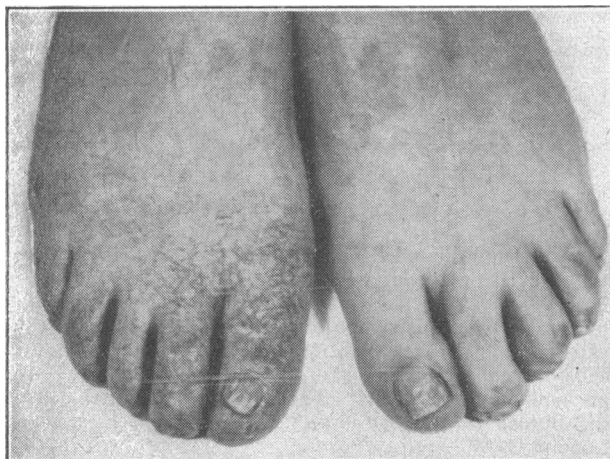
Typical x-ray dermatitis of right foot.
